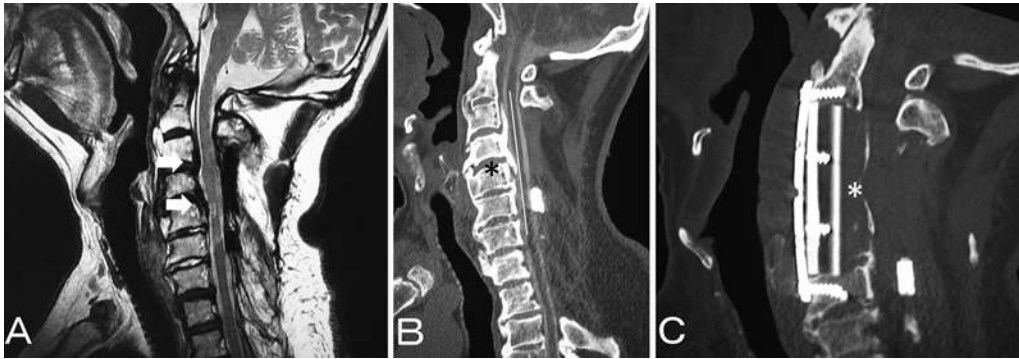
Case 19. A: MR image obtained before revision ACDF, showing anterior cord compression from C-3 to C-5 (arrows). B: CT myelogram obtained before revision ACDF, showing discontinuity of the ossification at C-5 (asterisk), meaning that residual motion exists at this portion. The maximum thickness of the ossified PLL was 8 mm. The K-line (white line) was plus. C: CT scan obtained after revision ACDF, showing adequate anterior decompression (asterisk).
